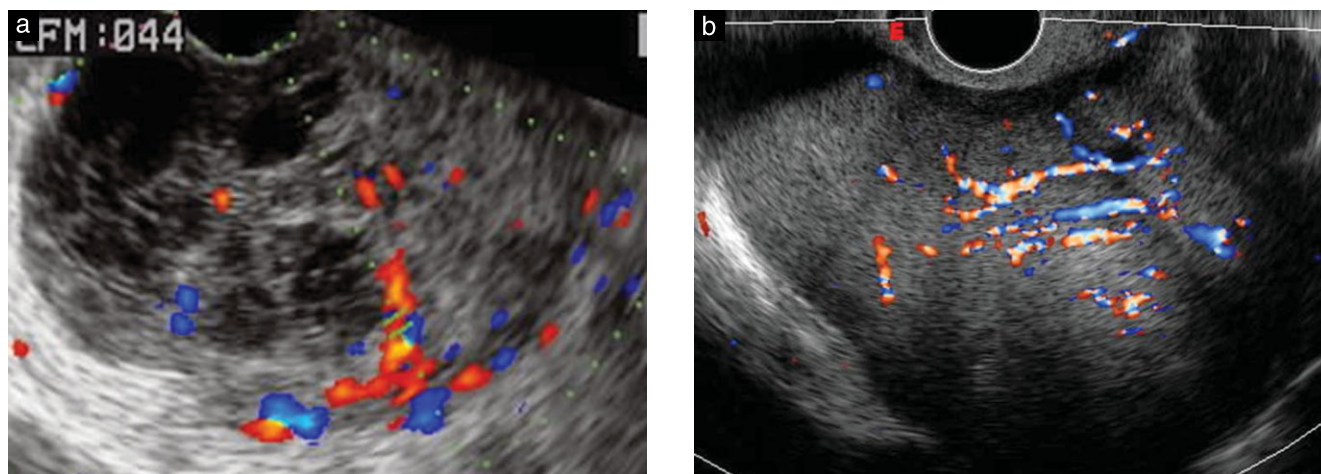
Color Doppler ultrasound images of (a) an ovarian metastasis derived from colon cancer with vessels within the septa (color score 2) and (b) an ovarian metastasis derived from gastric cancer (color score 3).
